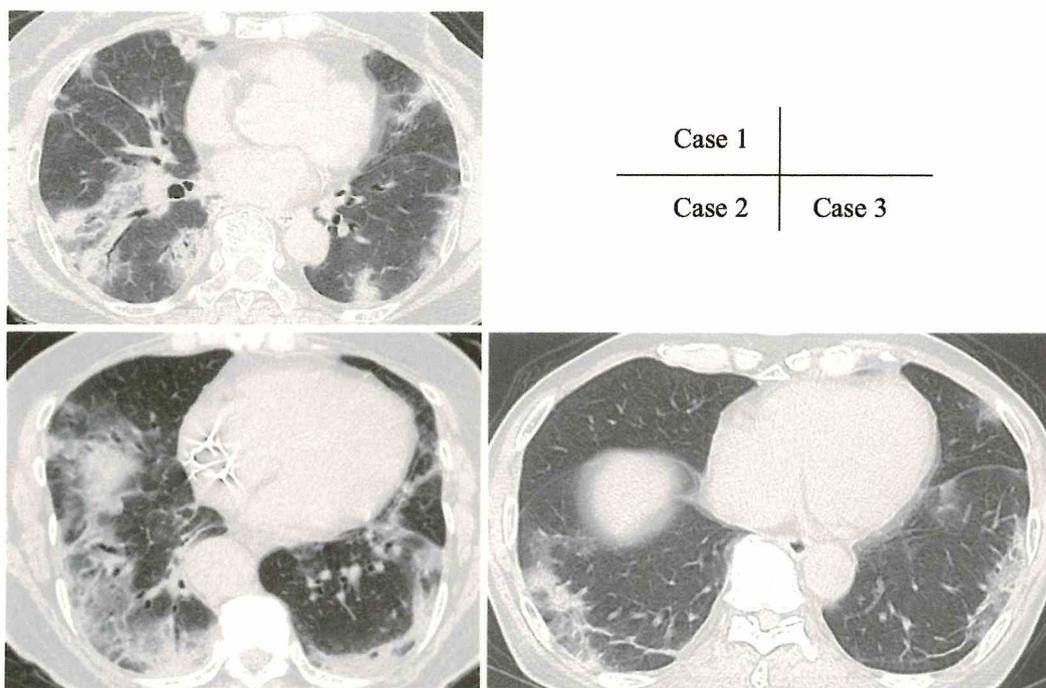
Findings on high-resolution computed tomography of the chest at the time of admission. Patchy distribution of areas of consolidation accompanied by traction bronchiectasis (case 1). Peripleural ground-glass opacity and areas of consolidation accompanied by traction bronchiectasis (case 2). Peripleural ground-glass opacity and areas of consolidation (case 3).
